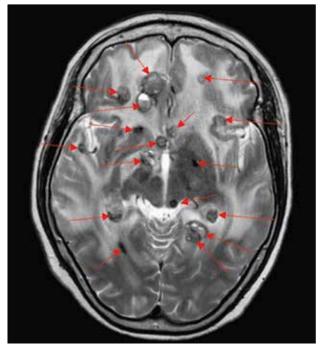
T2-weighted axial image taken in March 2024 shows further disease progression, with interval increase in the size and number of metastatic lesions (arrows), as well as extensive cerebral oedema.
